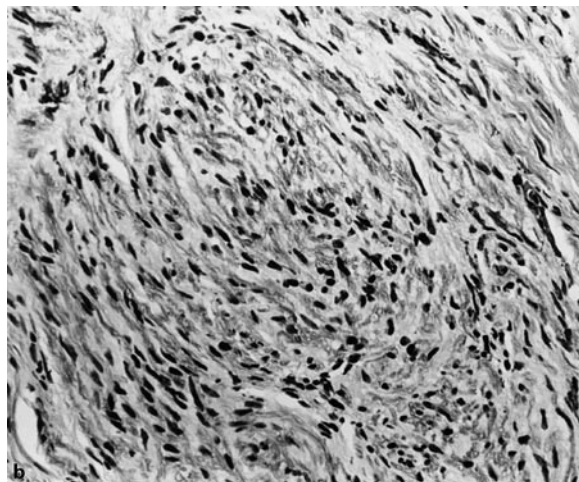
a Contrast MRI in a patient with recurrent vertigo 6 months after a successful labyrinthectomy for Ménière's disease. There is enhancement in the region of the vestibule (arrow). b Removal of the mass by intact canal wall mastoidectomy revealed disorganized myelinated and unmyelinated nerve fibers
